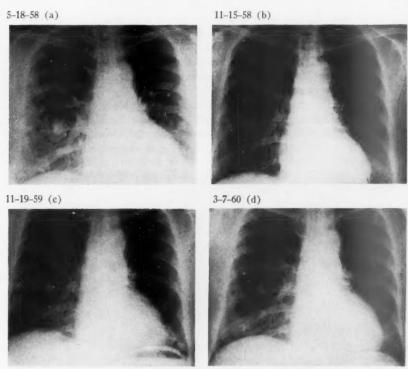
Chest x-rays of case 6, who responded to two separate courses of o.p'DDD. a and b reflect the first course (900 gm. o.p'DDD); c and d reflect the second course (700 gm. o.p'DDD).
